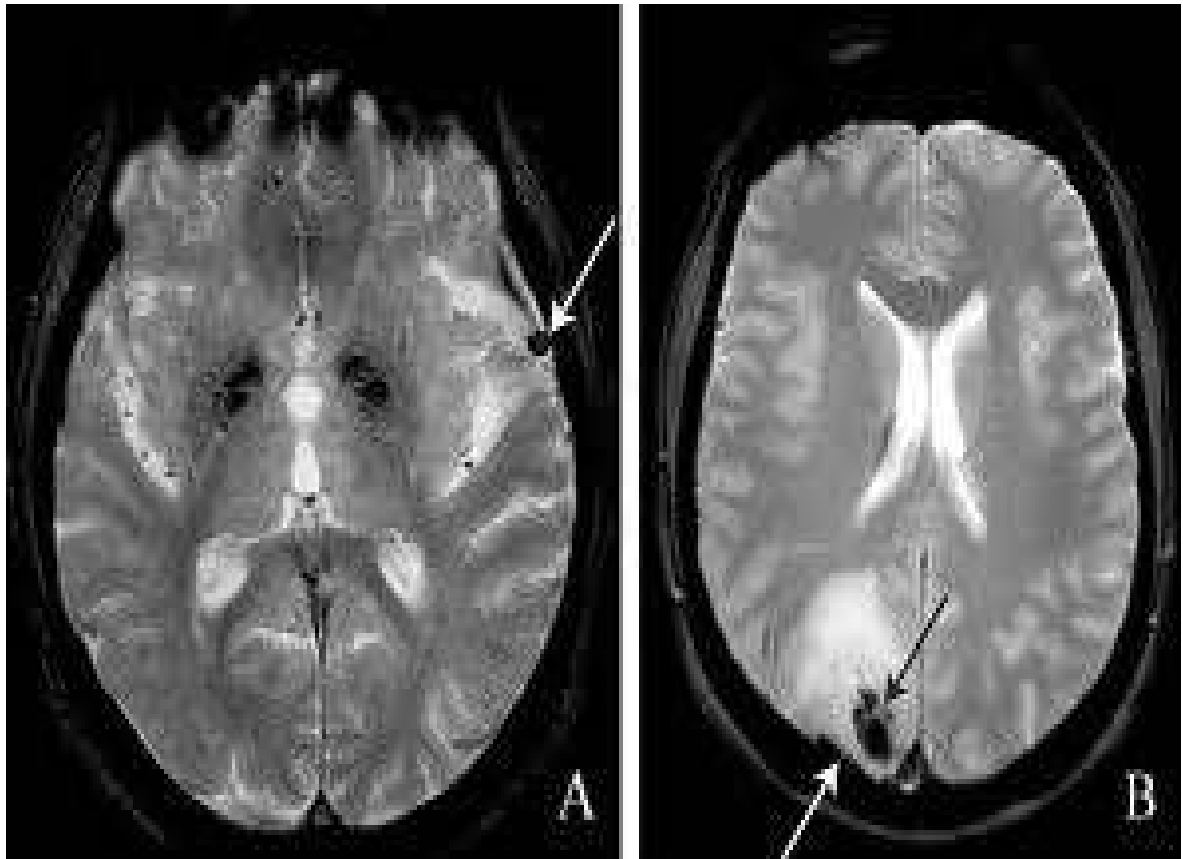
MRI Brain showing transverse sinus thrombosis
